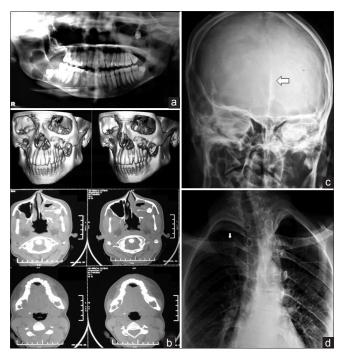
(a) Orthopantomogram showing multiple cystic radiolucencies. (b) Computerized tomography with three-dimensional reconstruction showing extent of the lesions. (c) Radiograph of skull showing calcification of falx cerebri. (d) Chest radiograph showing bifid ribs
